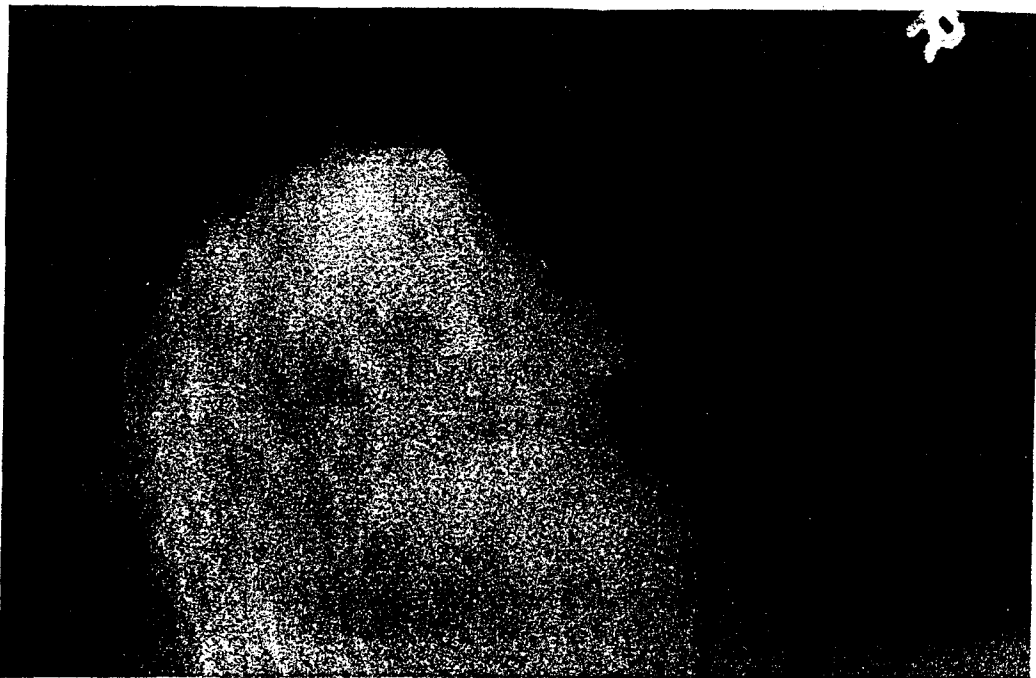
(a) Right side breast, x-ray image.
